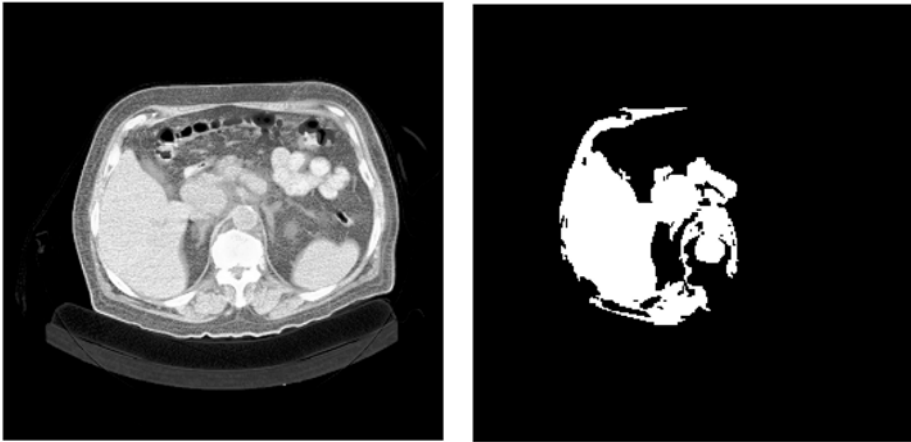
(a) Original helical, contrast enhanced CT slice with a tumor at the head of the pancreas indicated by black arrow. (b) Region based segmentation using ITK software on Fig. 4.6(a).
